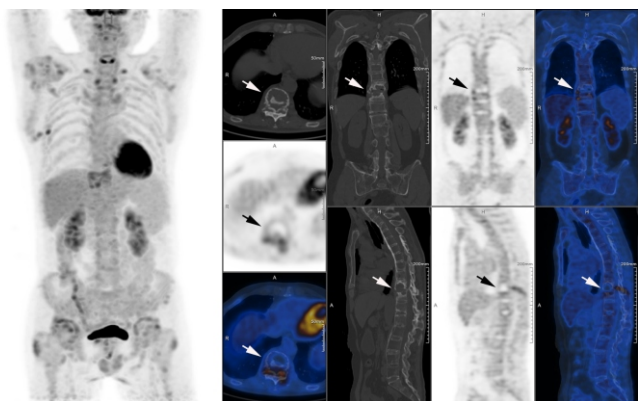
Fluorine-18-FDG PET/CT images show "bamboo-like changes" in the spine, narrowing of the intervertebral space, vertebral facet and sacroiliac joints and partial fusion with abnormal ^{18}F -FDG uptake (SUVmax:5.6). The lesion in the T10-T11 (arrow) was diagnosed as AL.
